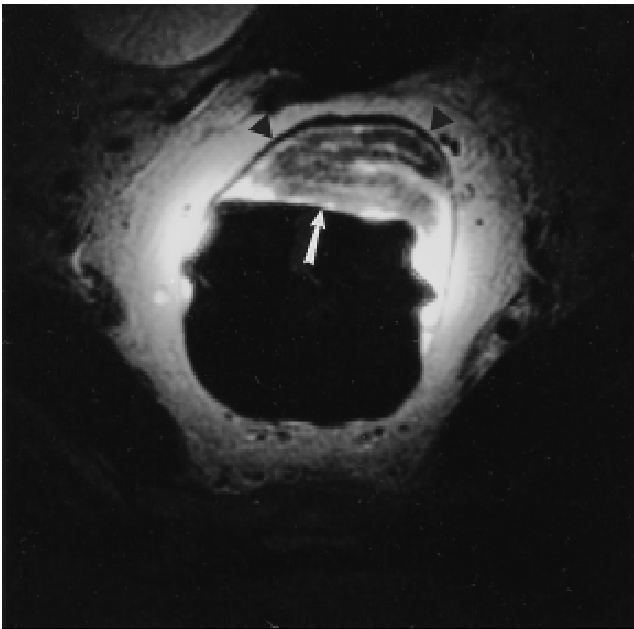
Endorectal MR image and endoscopic rectal sonogram of a stage T2 adenocarcinoma. A. Axial T2-weighted endorectal MR image demonstrates a well-defined mass (arrow) within an intact muscularis propria layer (arrowheads). B. Axial endorectal sonogram of the same patient also demonstrates the mass (arrow), which is superficial (stage T2) to the muscularis propria layer (arrowheads).
